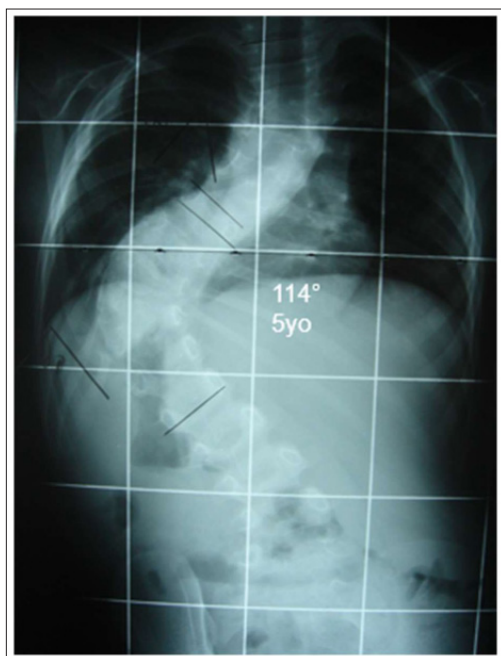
AP X-Ray view of the Spine at Five Years Old with a Cobb Angle of 114°
